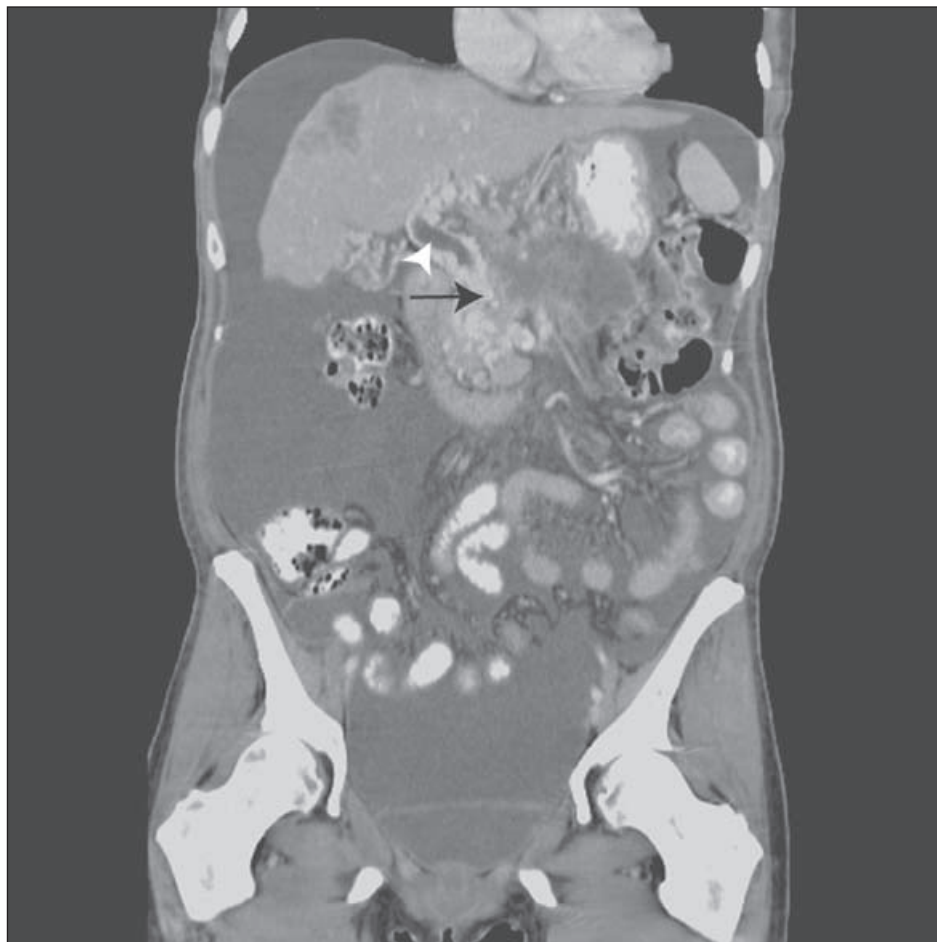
High-resolution CT scan coronal reconstruction of portal anatomy in a patient with ductal adenocarcinoma of the body of the pancreas. Note the portal vein occlusion with cavernous collateral transformation (narrow arrow). In addition, the patient has liver metastases with bile duct obstruction and malignant ascites. (Photo courtesy of Dr Joseph Collins.)
